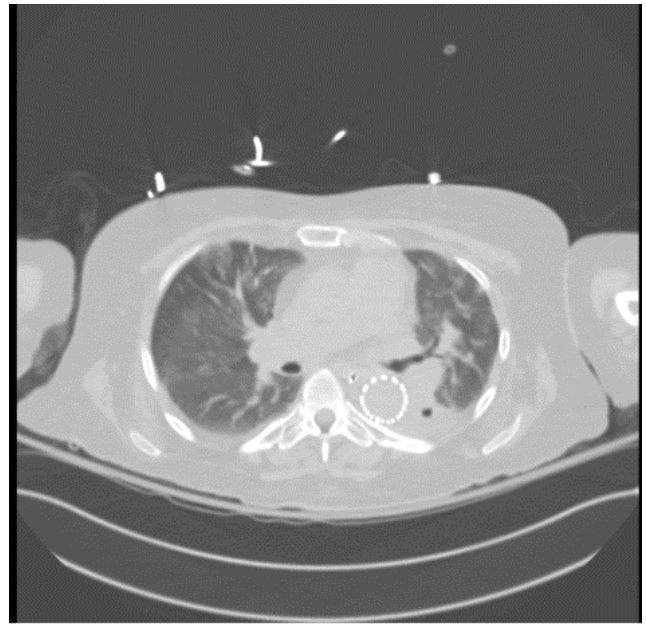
Chest CT obtained on day of admission to this hospital showing a cavitary lesion in left lung with infiltrate and an effusion, and a minimal right lung effusion.
